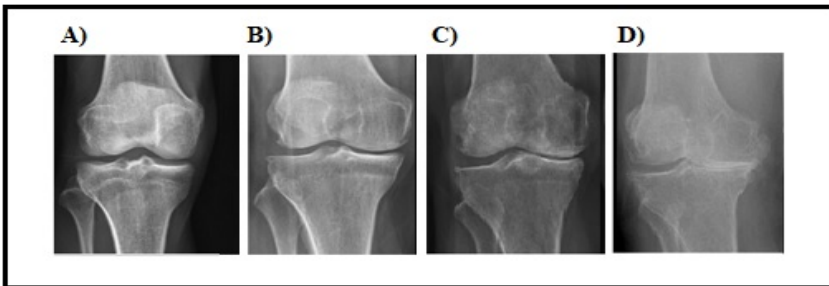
Knee radiographic image of the KOA patients according to KL grading; (A) Grade 1, (B) Grade 2, (C) Grade 3, (D) Grade 4.
